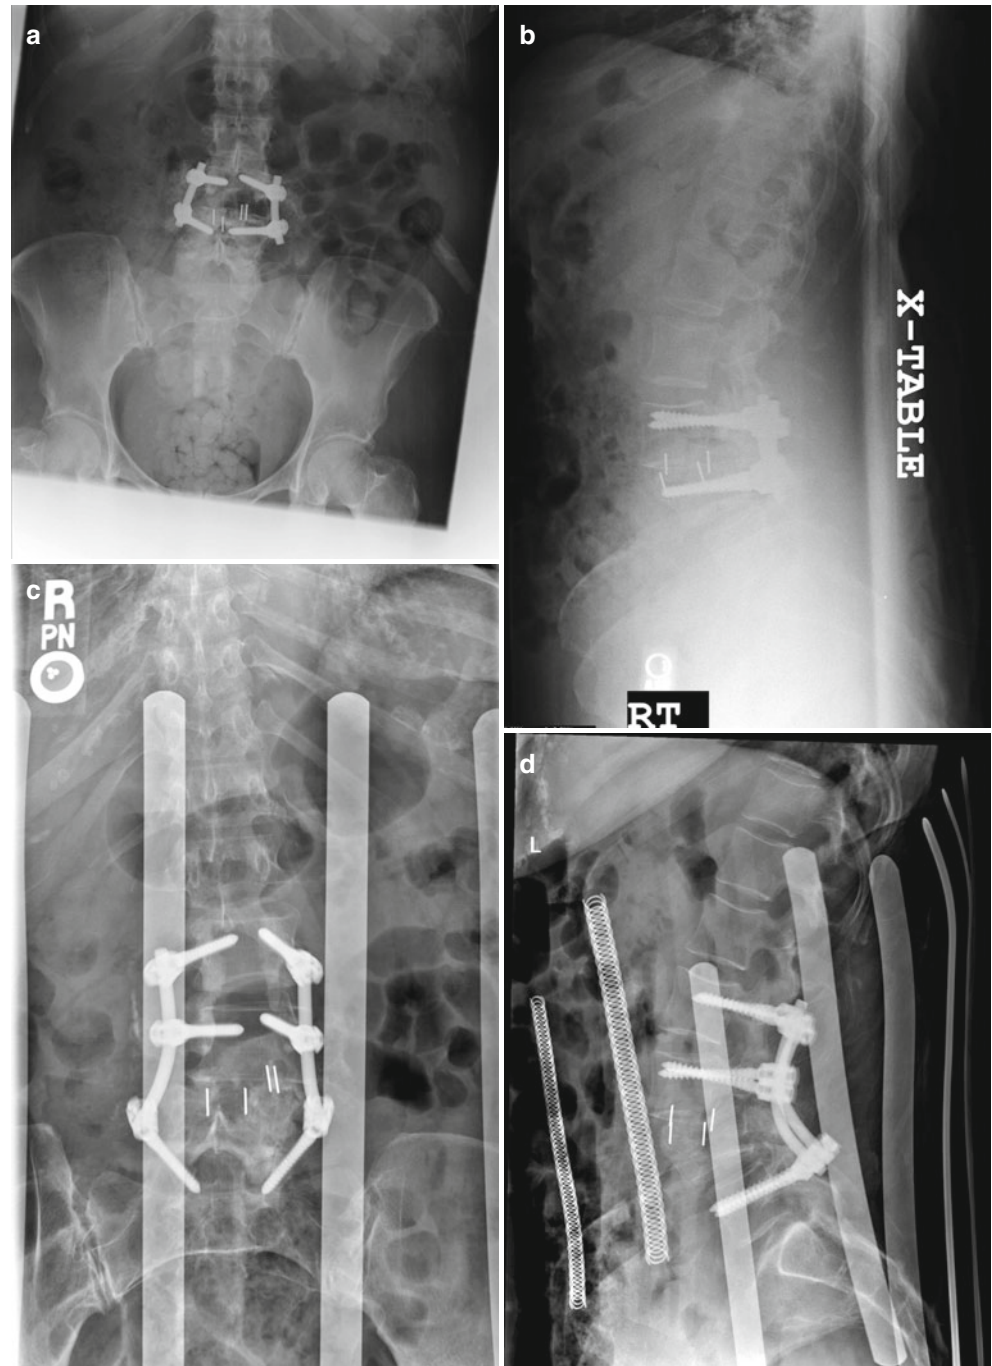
Postoperative AP (a) and lateral (b) imaging of a 72-year-old female after MIS TLIF placed with MIS instrumentation as her index procedure. The TLIF cage fractured through the vertebral end plates, and the patient developed bilateral lower extremity weakness. AP (c) and lateral (d) imaging after the initial surgeon revised the failed TLIF by extending decompression and fusion. The patient presented to our facility with continued bilateral lower extremity weakness and extensive bone loss as shown on sagittal CT imaging (e). The patient then underwent staged revision at our facility with posterior decompression and fusion from L1 to the pelvis, removal of the fracture fragments, and placement of iliac bolts during Stage 1. Stage 2 involved L3–L4 anterior corpectomy and fusion with an expandable cage placement. Final AP (f) and lateral (g) imaging after two-stage revision
